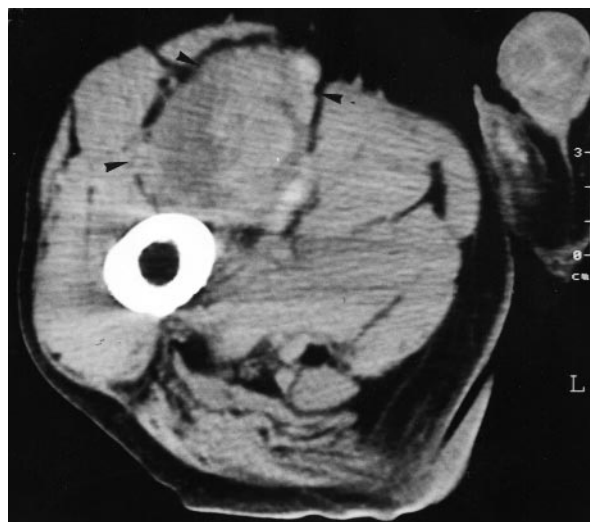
Pseudoaneurysm of right superficial femoral artery on computed tomographic scan. The arrowheads indicate the pseudoaneurysm.
